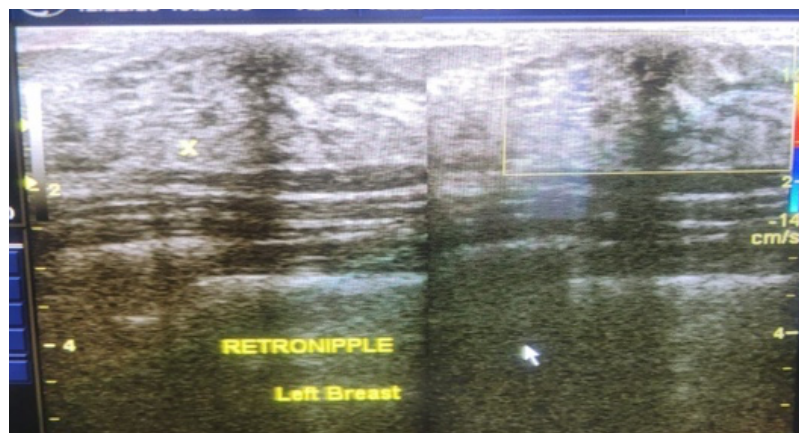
Breast Ultrasound Examination
